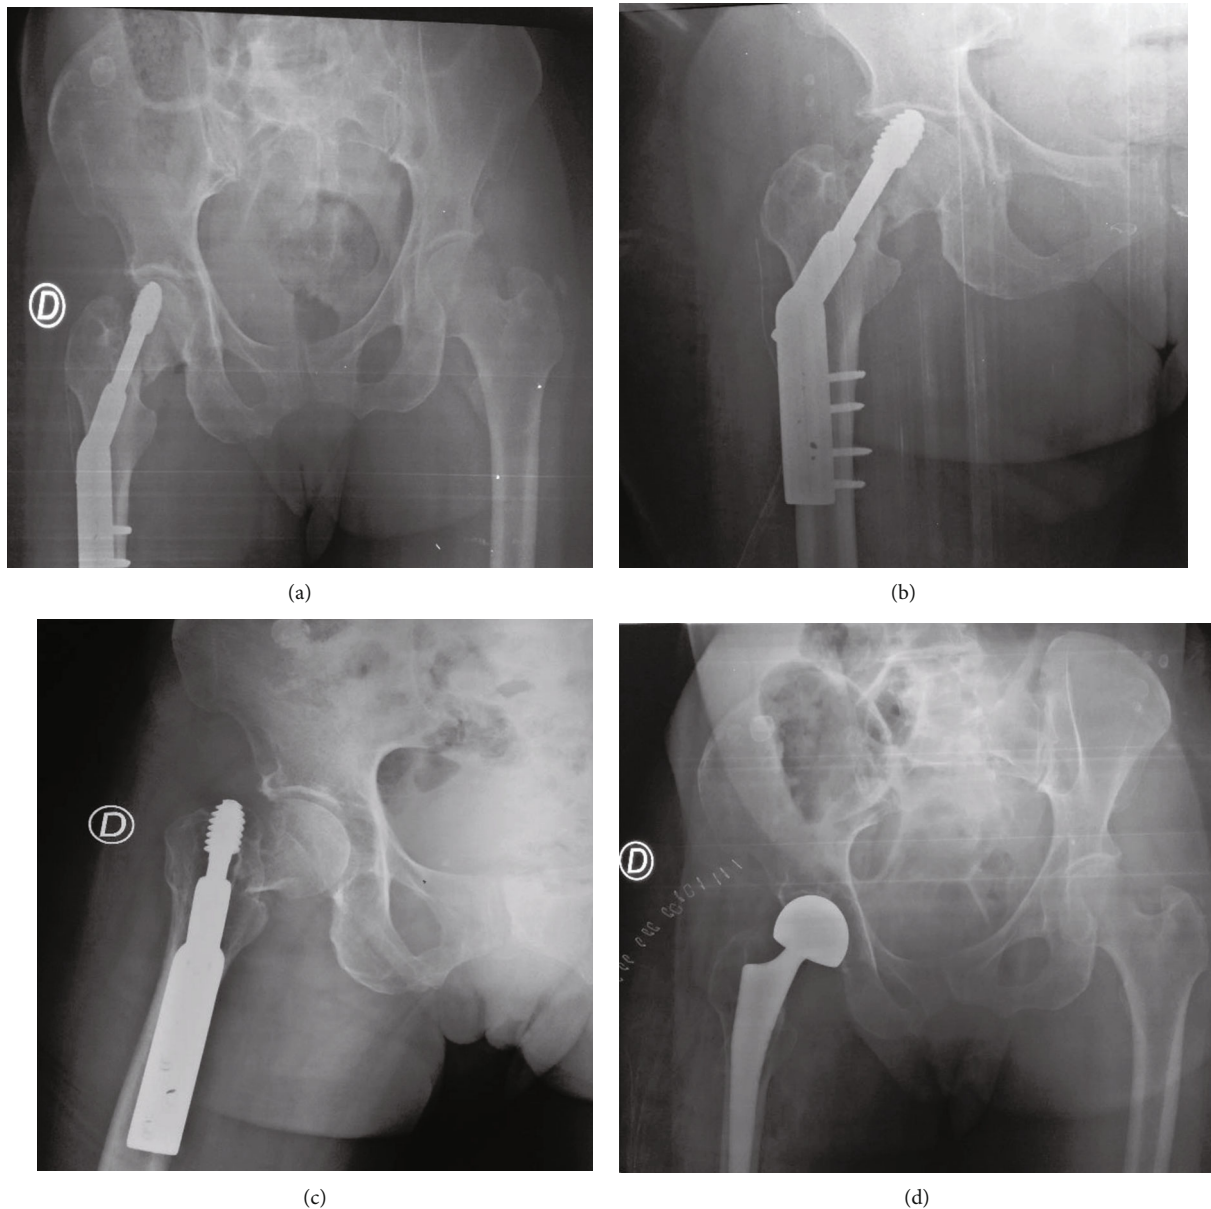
X-rays of patient 2. (a) DHS osteosynthesis of neck fracture. (b) Neck pseudarthrosis with phenomenon. (c) Cut out phenomenon with cephalic osteonecrosis. (d) Right hemiarthroplasty.
